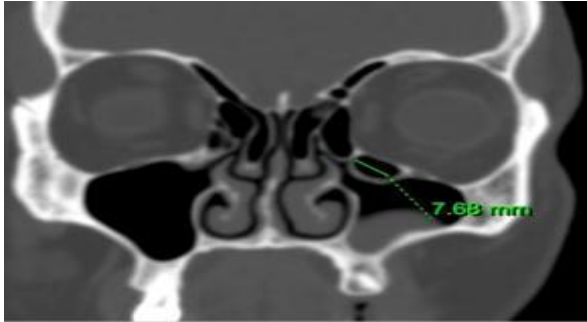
Coronal section of CT-PNS demonstrating patent left haller cell not obliterating OMC.
